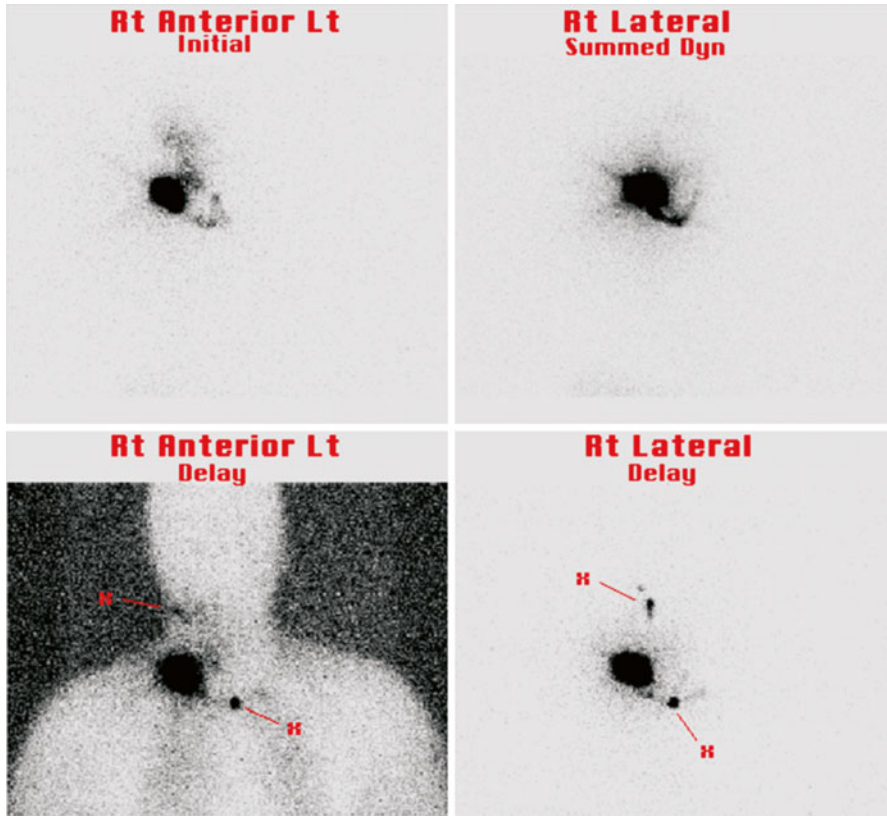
A right cervical cutaneous SCC showing lymphatic drainage to right level II and left level IV sentinel nodes (Image provided by Professor Roger Uren, Alfred Nuclear Medicine and Ultrasound, Sydney, NSW, Australia)
